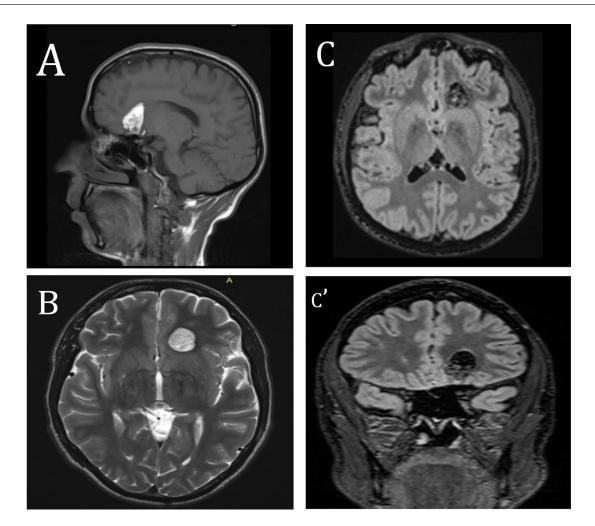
Images showing intra-axial lesion with a hypersignal on T1-weighted image on sagittal section (A), with hypersignal on axial section on T2-weighted image (B) and heterogenous hypersignal on FLAIR on coronal and axial sections (C and C').
